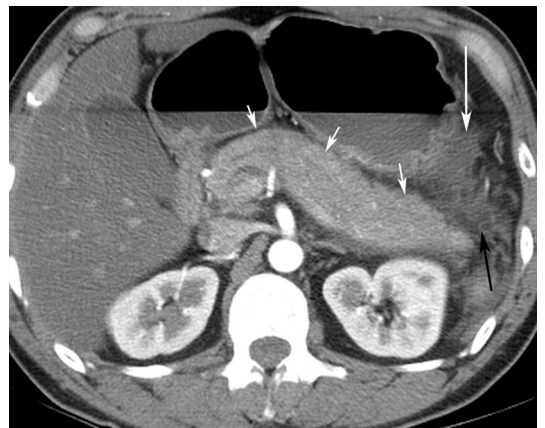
Acute interstitial edematous pancreatitis with a single peripancreatic fluid collection, CTSI 3. A CT image in the axial plane of a 55-year-old woman demonstrates a swollen pancreas (short white arrows), which enhances heterogeneously. Peripancreatic stranding is evident (black arrow), and a single peripancreatic fluid collection (APFC) is identified next to the stomach (long white arrow).
